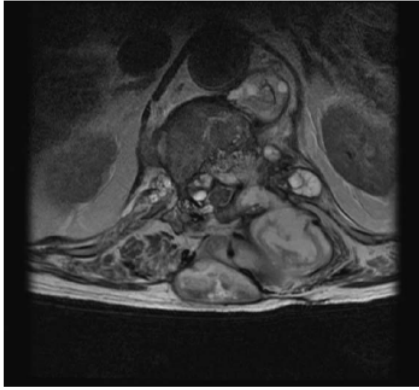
Transverse section MRI shows a paravertebral mass with destruction of T11, intraspinal invasion, and medullary compression.
